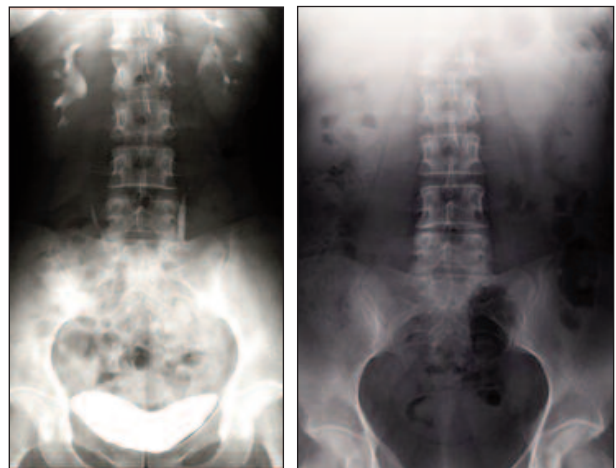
Man 39 yrs old admitted to our clinic for right flank pain. A, B, X-Ray plus urogram showed bilateral nephrolithiasis, more evident on the right kidney. The patient was given potassium citrate (4 g per day orally in 2 doses).
